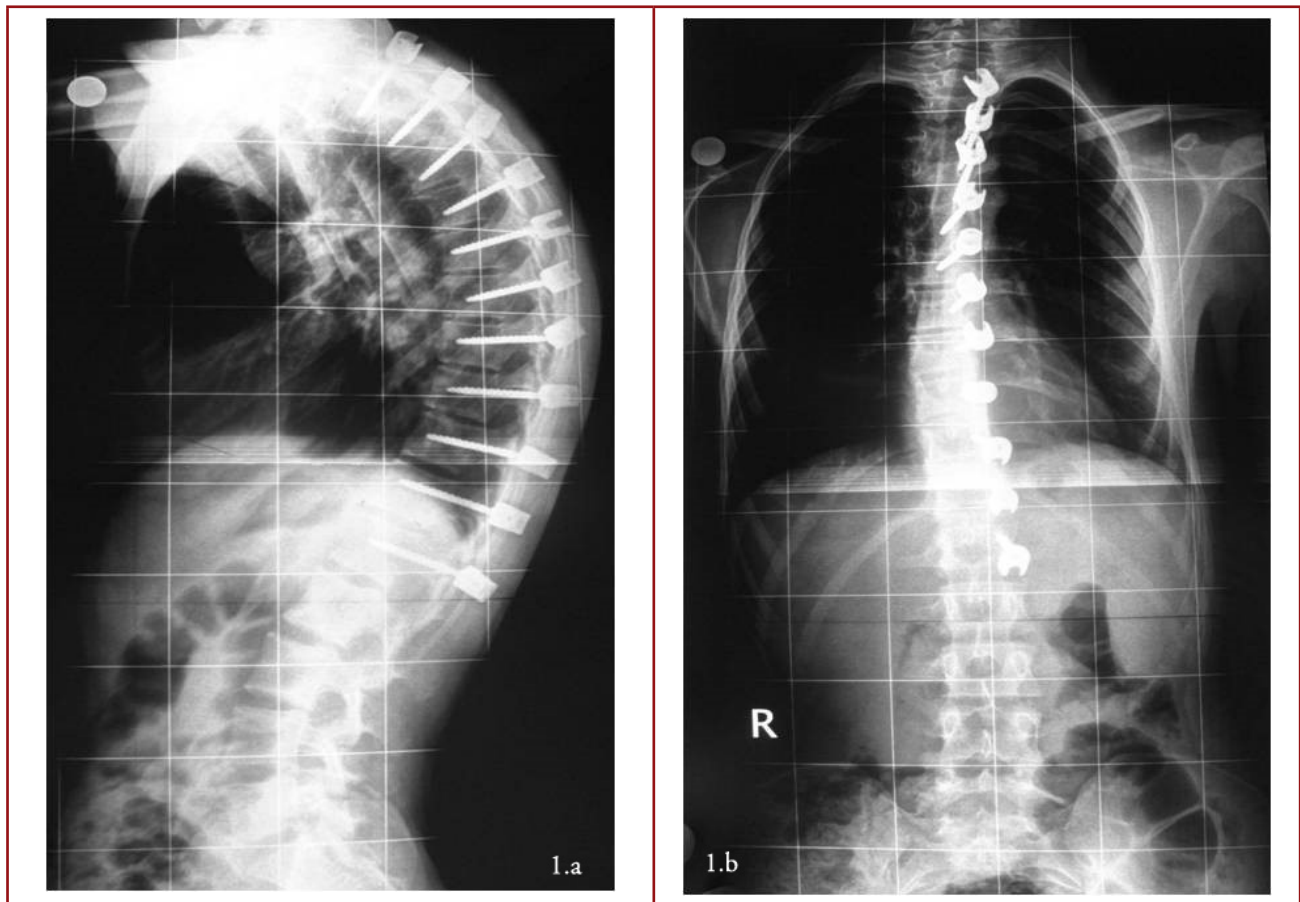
a. Postoperative lateral radiographic image. b. Postoperative AP radiographic image
